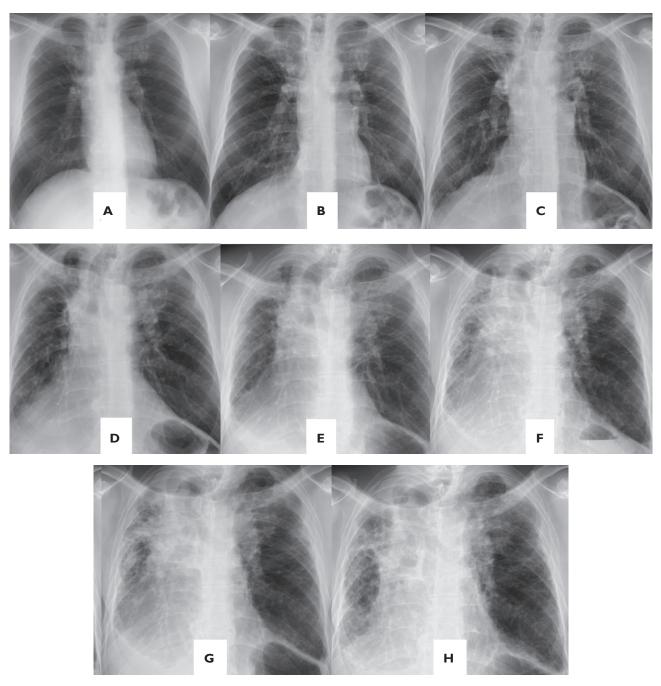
Changes in chest radiographs over time. Chest radiograph taken just before resection of renal cancer 64 months before onset (A); chest radiograph taken 34 months before onset (B); chest radiograph taken 8 months before onset (C); chest radiograph taken at onset of pleuroparenchymal fibroelastosis (D); chest radiograph taken 8 months after onset (E); chest radiograph taken 18 months after onset (F); chest radiograph taken 25 months after onset (G); and chest radiograph taken 36 months after onset (H).
